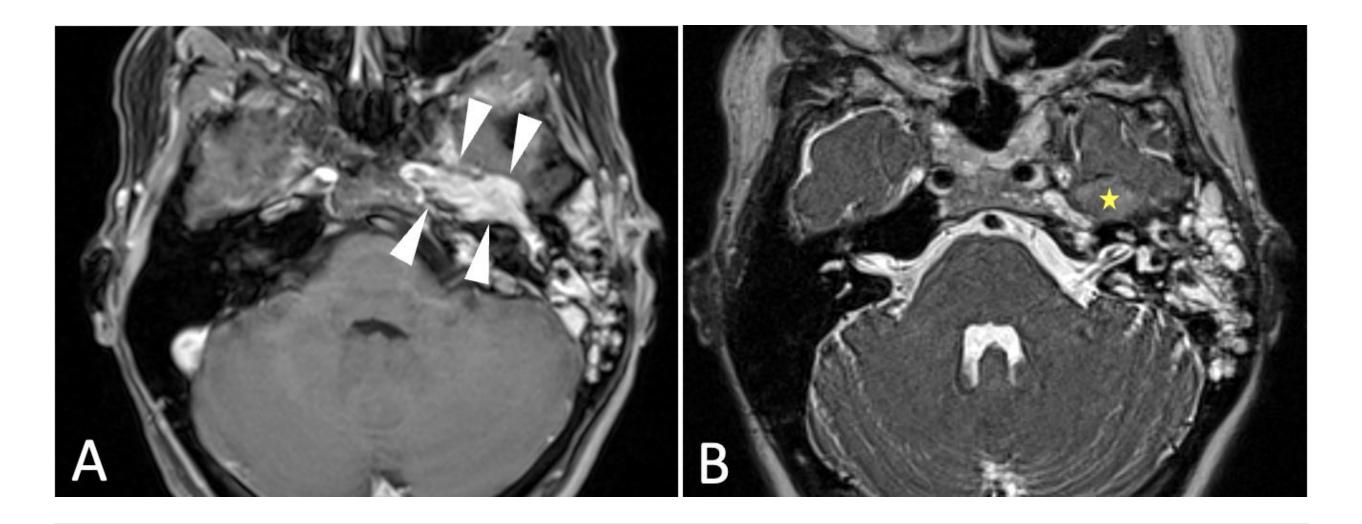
A) MRI post-contrast showing a large homogenously enhancing mass on T1 (arrow heads) extending from the foramen lacerum to the cavernous sinus with protrusion into the epitympanum; and an B) isointense mass with compression of petrous carotid on T2 (star).
